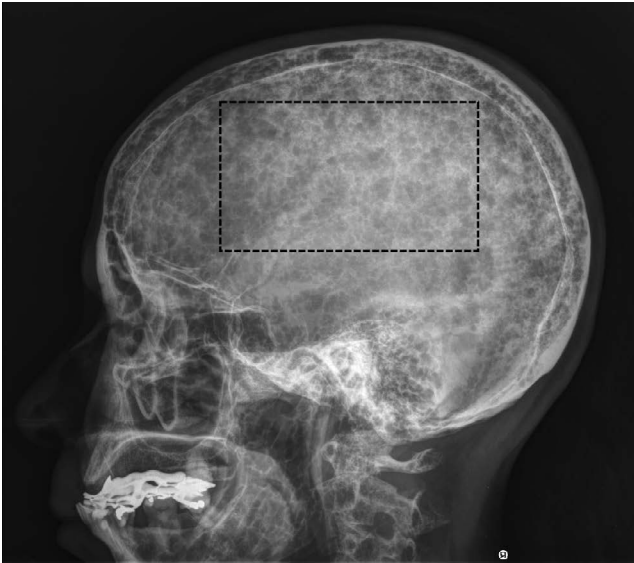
Location of the region of interest (black rectangle) on the trabecular bone of the neurocranium on a lateral skull radiograph.
